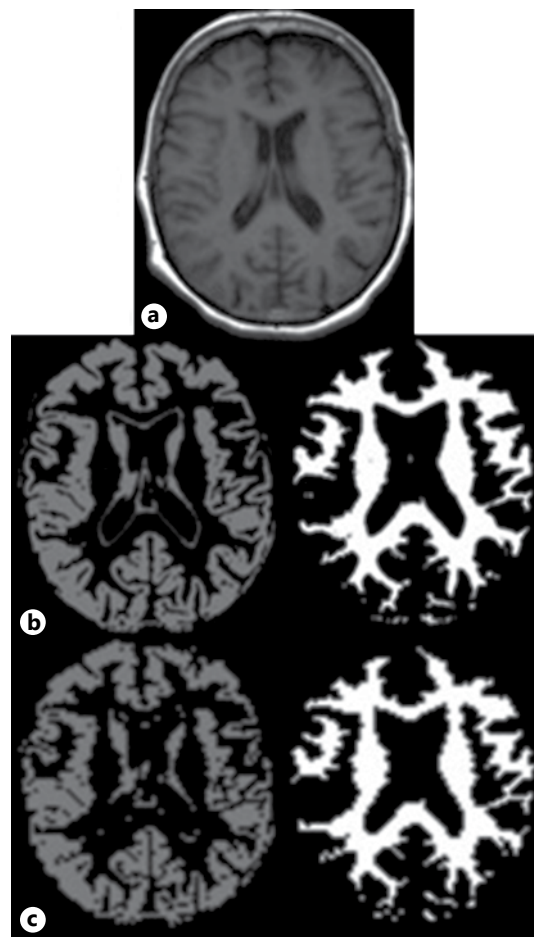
Individual T1 segmentation. From the original T1-weighted image (a), GM (light gray, left) and WM (white, right) masks were obtained after segmentation (b) and co-registration to the initial ADC map (c).
